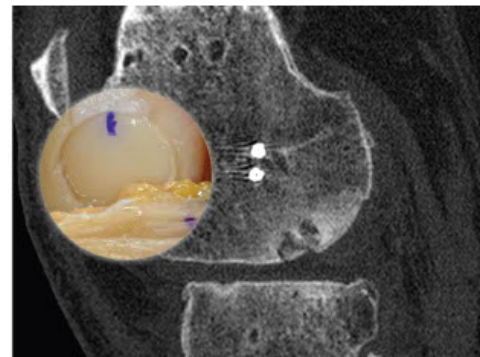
A computed tomography scan taken at 6 months after surgery and a surgical image of a medial femoral condyle fresh osteochondral allograft obtaining a high assessment computed tomography osteochondral allograft score (4 points—superior graft signal density relative to the host bone, discernible cleft ≤ 3 mm, cystic changes of graft > 3 mm).
